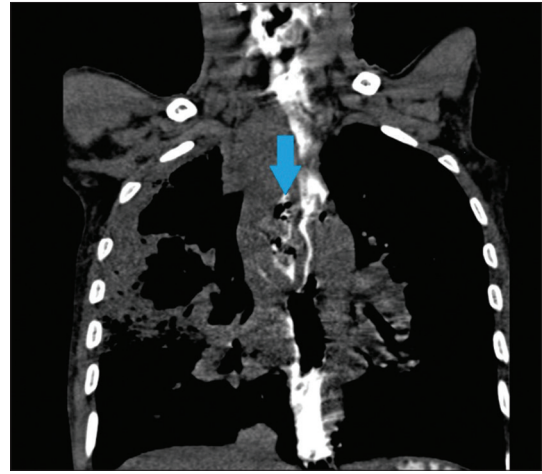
Coronal contrast (oral) multi-detector computed tomography scan image of thorax showing irregular filling of the upper thoracic esophagus with multiple air pockets in the mediastinum suggestive of pneumomediastinum (arrow)
